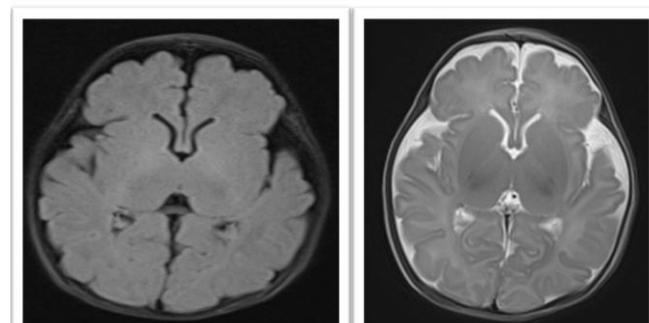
T1 W(Left) and T2W MRI images showed no significant abnormality.
